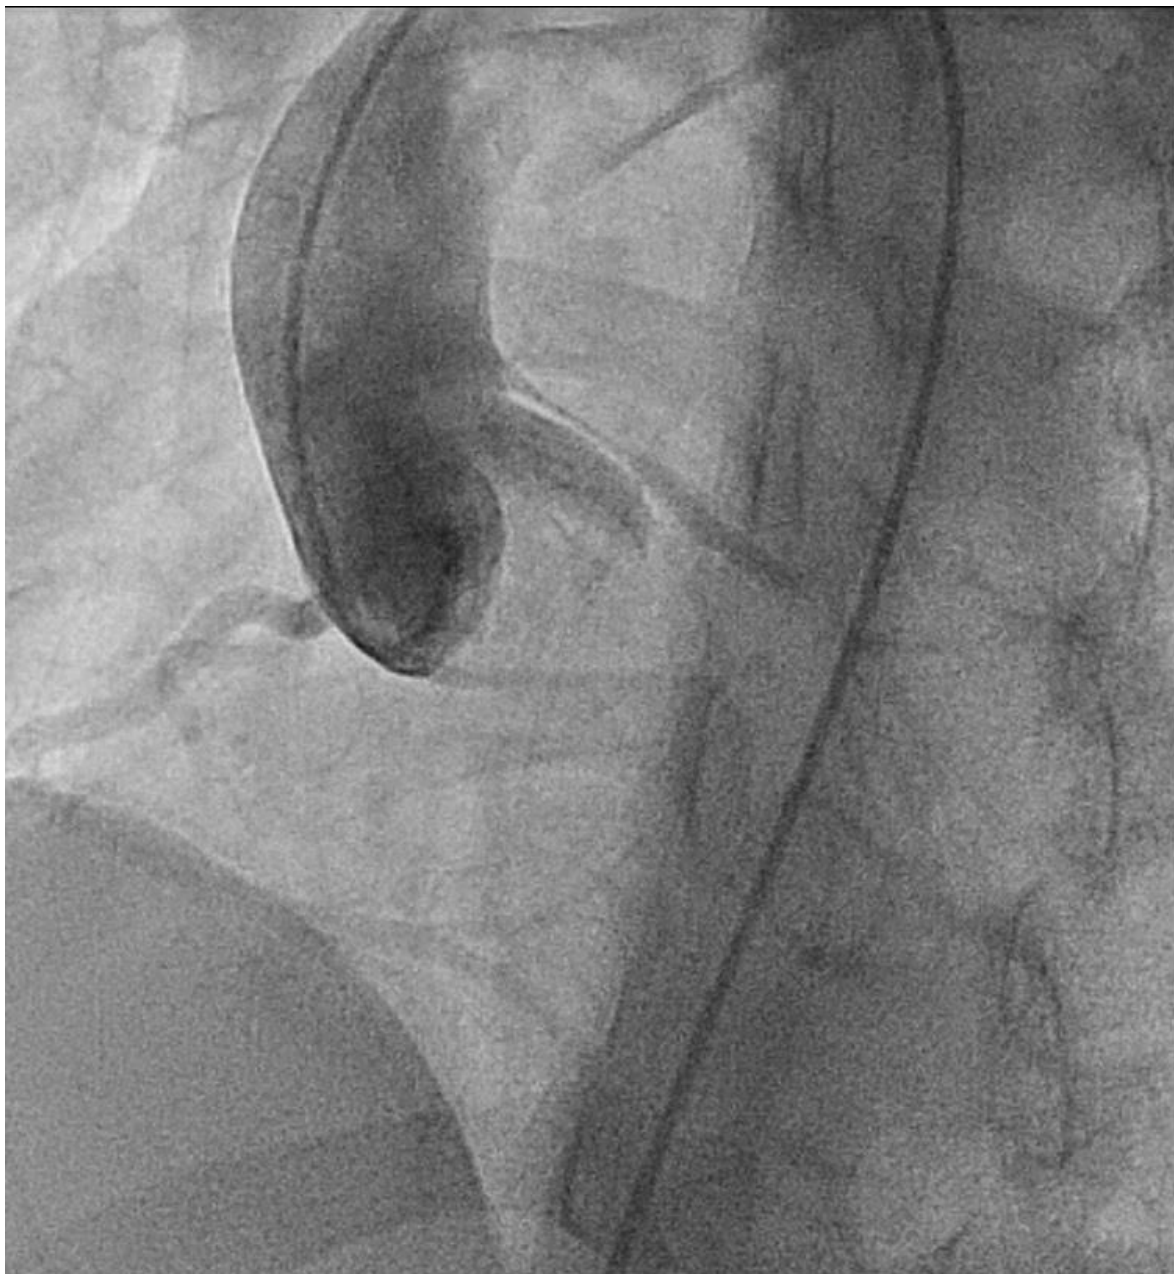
Extrinsic left main coronary artery compression by the enlarged pulmonary arteries. Cardiac CT also shows the anomalous origin of the left main artery above the sinus of valsalva.
